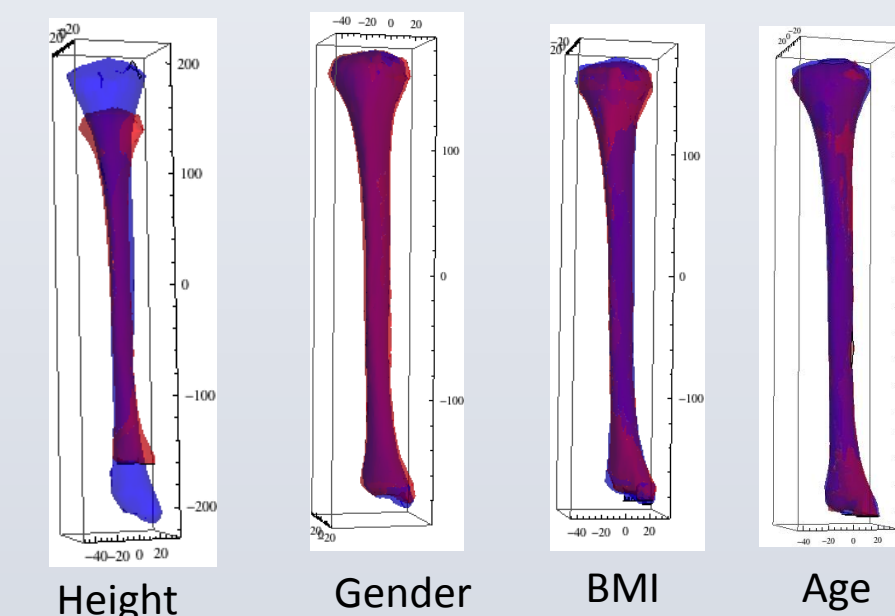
Images showing the effects of varying height, gender, BMI, and age on tibia shape over the ranges present in the CT dataset while holding other parameters constant.
